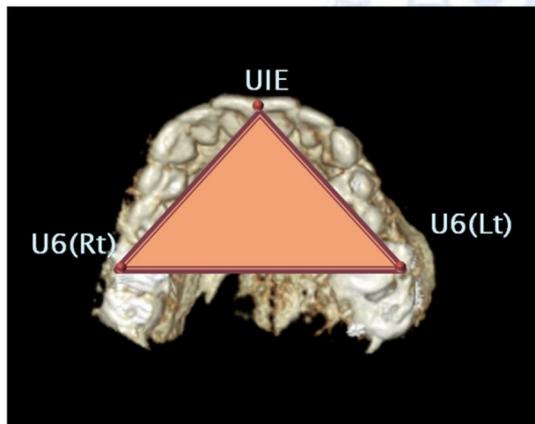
Linear measurements in 3D CT
